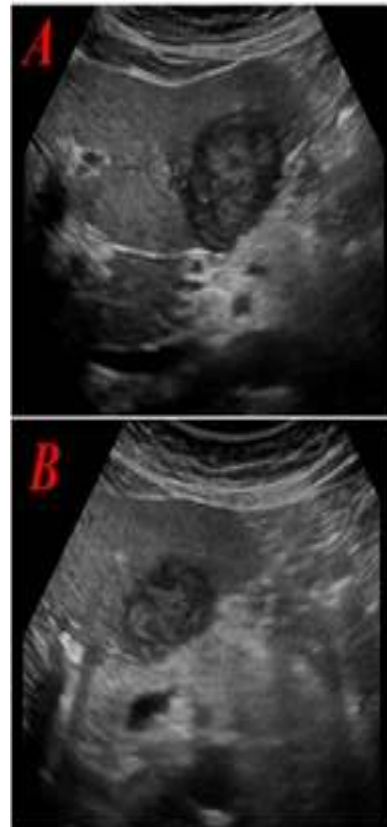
Sample images of small HCC from ultrasoundcases.info [2] (a), (b) and (c) contains Solitary Lesions.
